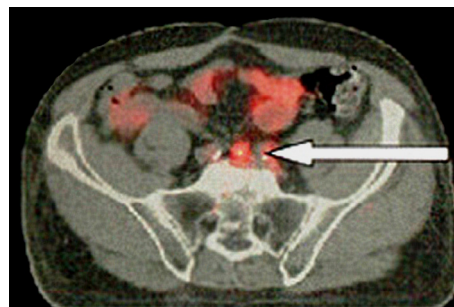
PET-CT showing sacral recurrence (arrow) following ISR.
